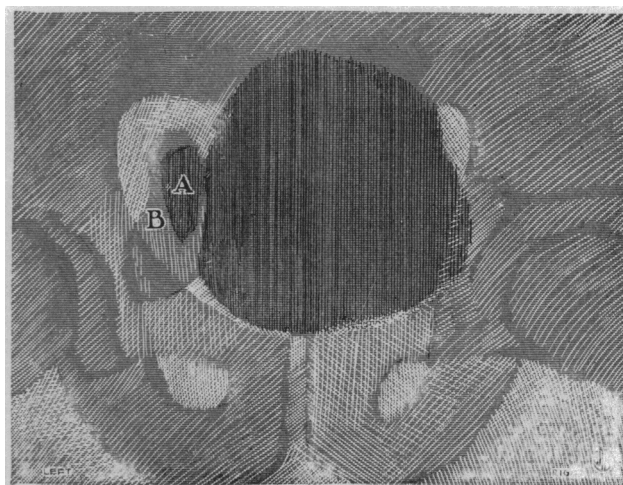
Diverticula (A, B) as shown by Roentgen ray (Case 5).
